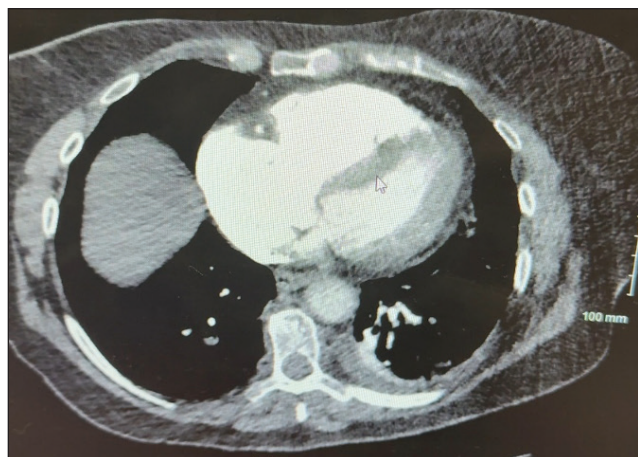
CT scan showing a dilated right ventricle and significant right heart strain (RV/LV ratio, 2.0).
